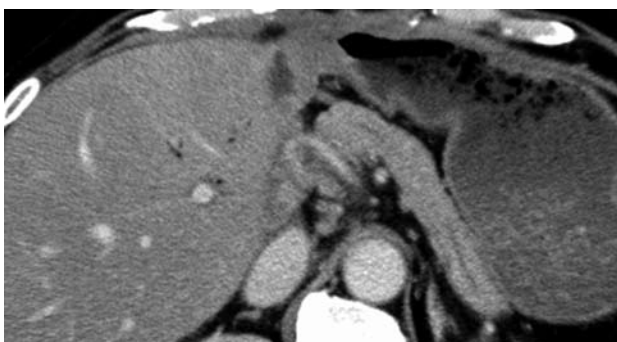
Computed tomography performed 14 d after removal of the drains in case 2 showing no fluid collection around the pancreas.
